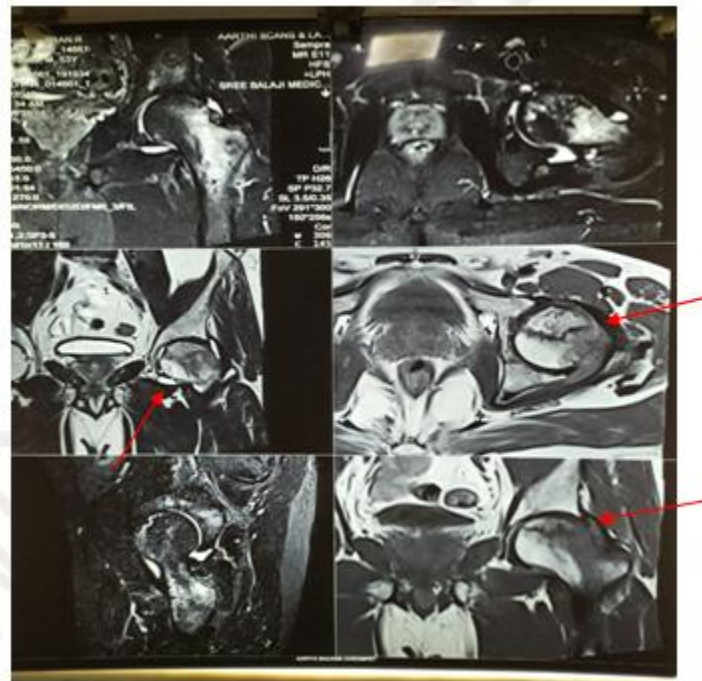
Magnetic Resonance Imaging (axial, coronal & saggital sections) of Left hip: Avascular necrosis of left femoral head with necrosis of >50% of femoral head represented by geographical areas (decreased intensity signals) on antero-lateral portion of the femoral head as depicted by arrows
